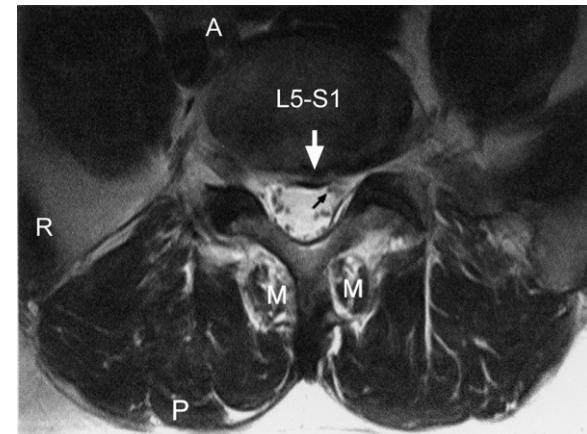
L5–S1 MRI axial T2-weighted image. Note: (i) the persisting L5–S1 posterior central to left paracentral disc protrusion (white arrow) presses upon the thecal sac and is close to the forming left S1 nerve root (small black arrow) and, (ii) there is early atrophy of the multifidus muscles (M). (Compare Fig. 24.4D which is almost in the same axial plane.)
